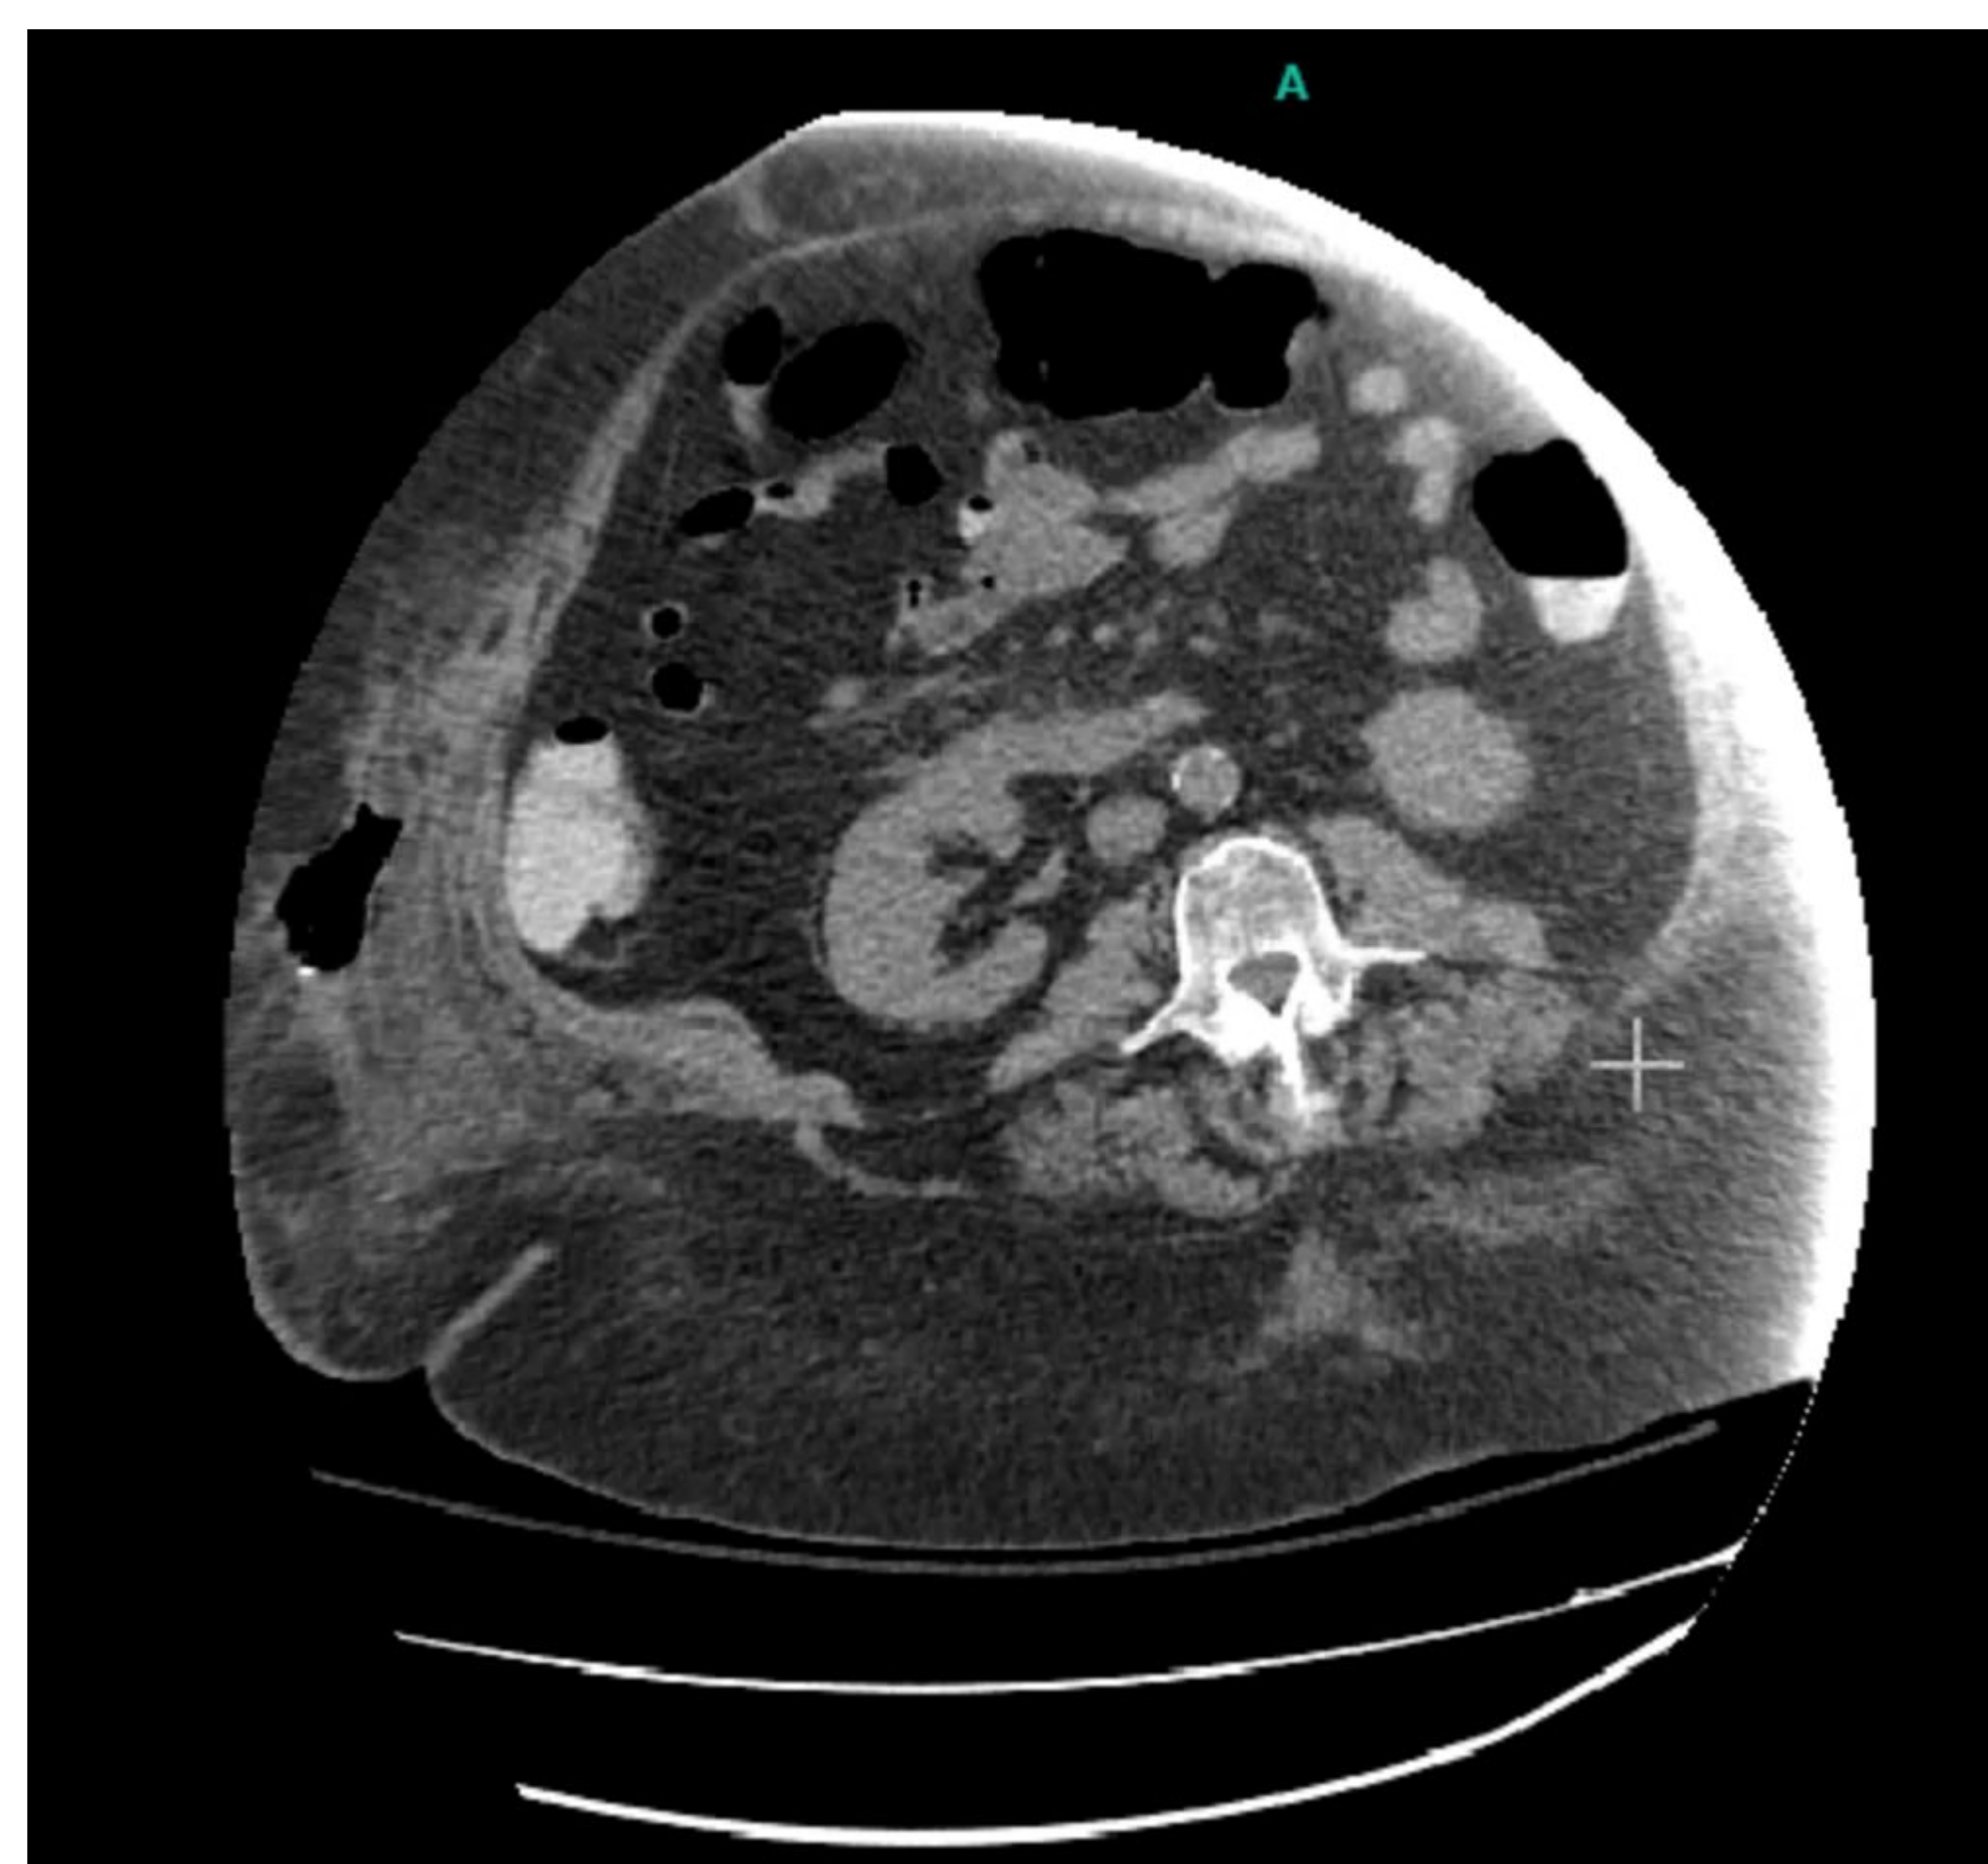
CT of abd/pelvis: 15cm x 20cm fluid collection overlying right abdominal wall
